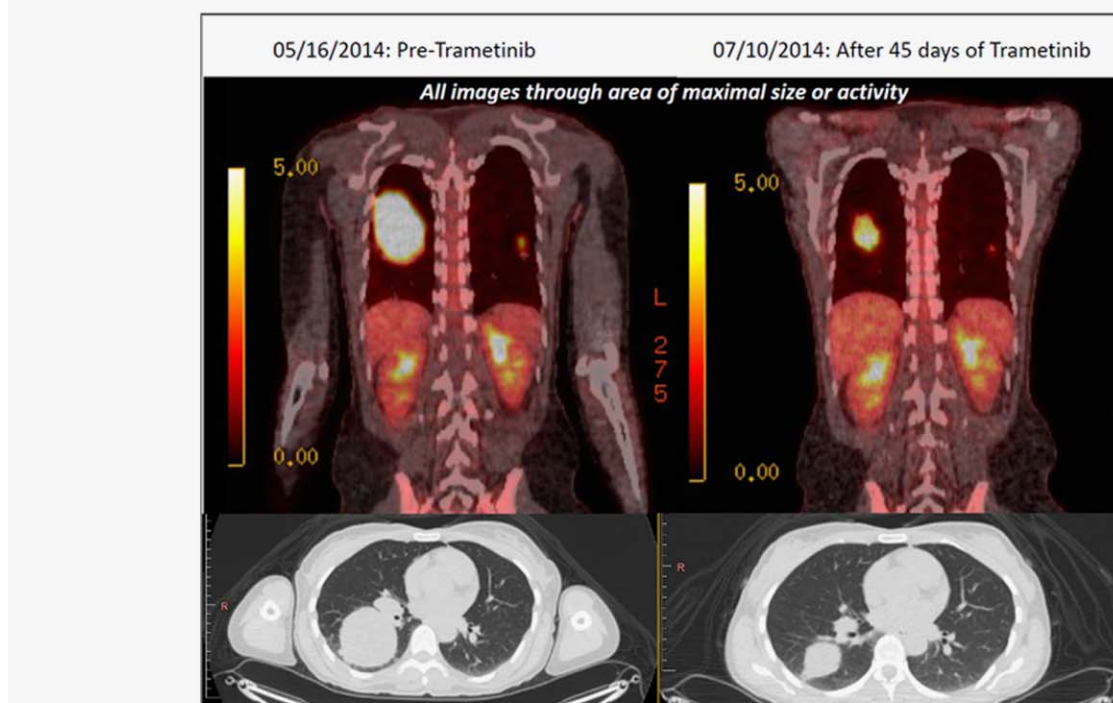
Fused PET/CT imaging results of trametinib therapy in a metastatic Spitzoid melanoma (Case 38) from a 46-year-old Caucasian woman that featured a ZKSCAN1-BRAF fusion (ZKSCAN1 exons 1–5–BRAF exons 10–18) and responded to the MEK inhibitor trametinib. Subcutaneous tumor nodules exhibited overt clinical responses within 14 days of therapy, and her dominant bulky right lung metastases showed significant response by Day 45 such that she subsequently underwent robotic-assisted lobectomy. The patient is currently alive with stable disease at 6 months post-thoracic surgery.
